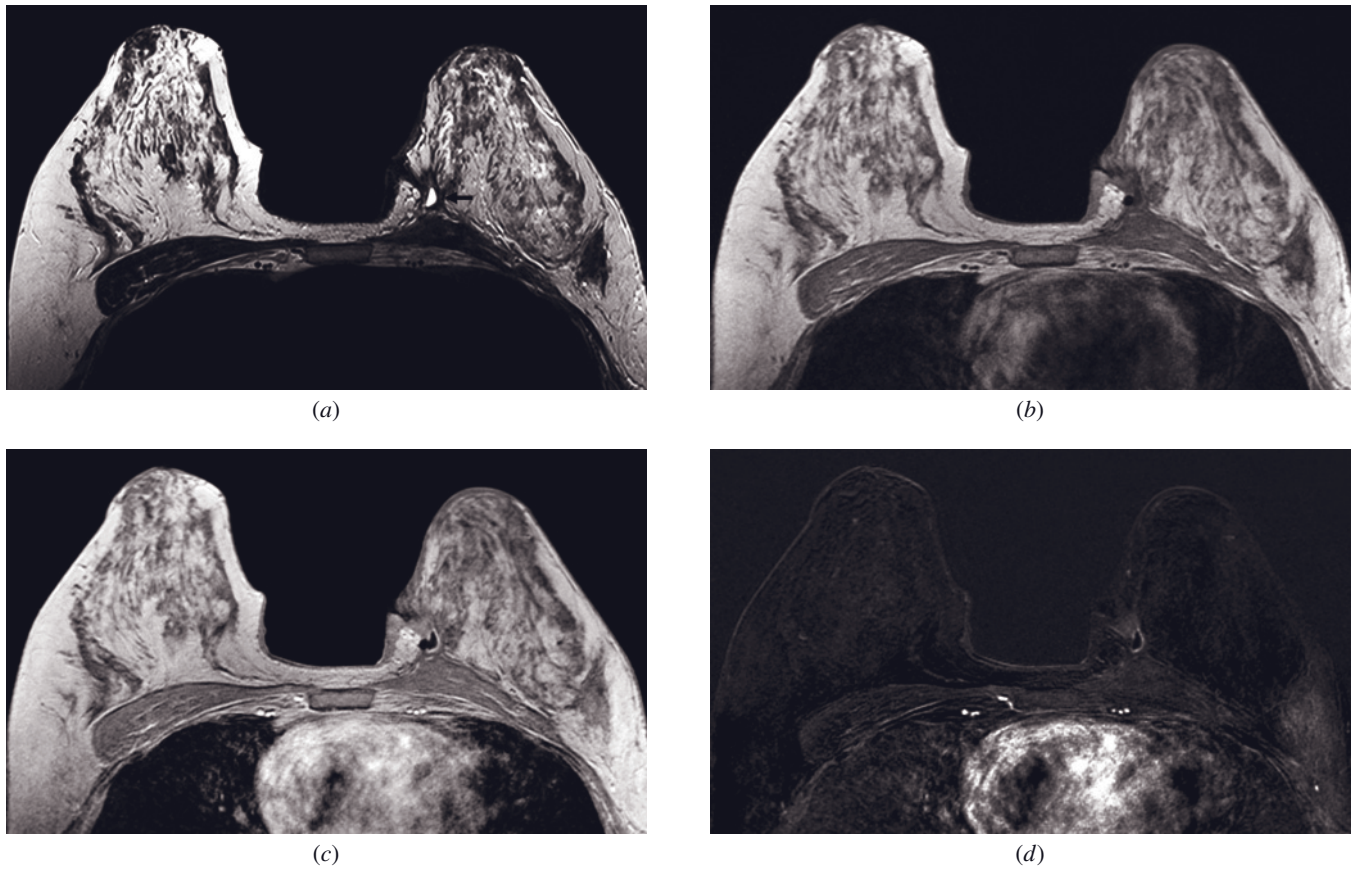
Postoperative site after BCT and radiation therapy of the breast. Postoperative site may show postcontrast enhancement up to 18–24 months after BCT and radiation therapy of the breast. Postoperative scarring with skin thickening and a small seroma (arrow, *a*) in the medial aspect of the left breast are shown on the axial T2-weighted (*a*) and T1-weighted GRE (*b*) images. Postcontrast T1-weighted GRE (*c*) and subtracted (*d*) images demonstrate thin, regular enhancing margin of the postsurgical cavity 1 year after surgery and irradiation, without any signs of residual cancer.
